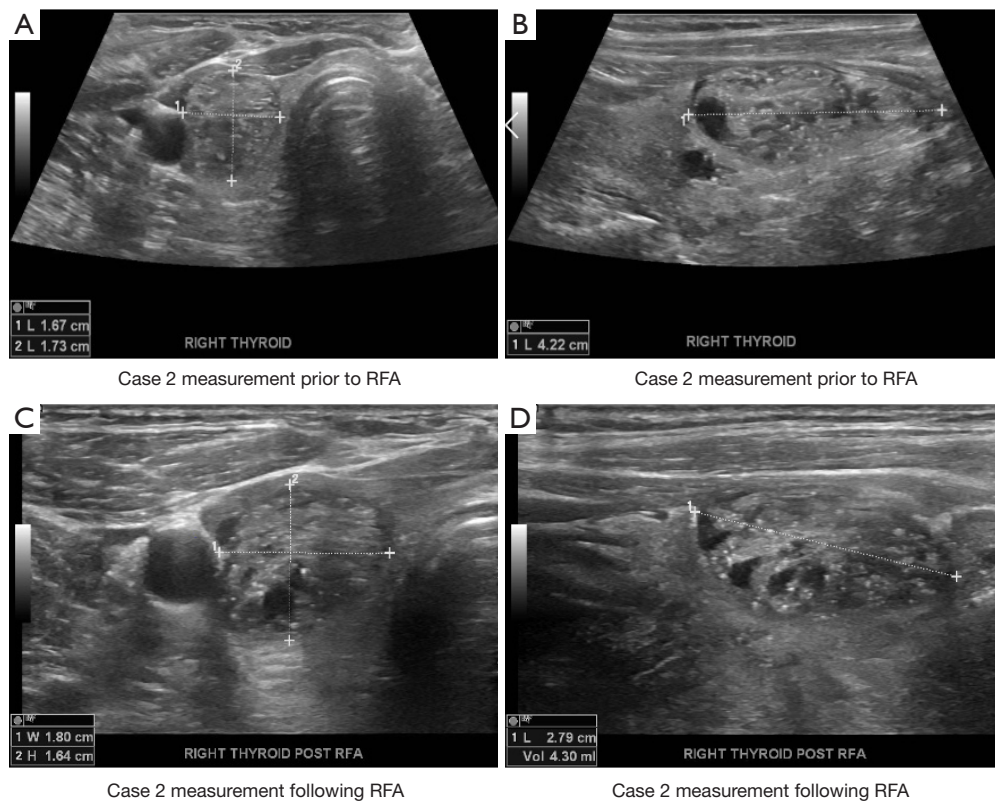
Sonographic images of case 2 prior to and one month following RFA. Volume decreased from 12.19 to 8.24 mL, indicating a 32.45% volume reduction rate. RFA, radiofrequency ablation.
